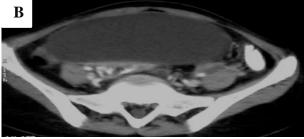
Computed tomography images. (A): Axial images of the same patient showing small bowel loops congregated in the centre of the abdomen encased by a soft tissue density membrane. Enlarged discrete lymph nodes are also seen in the mesentery (arrow head), (B): Loculated ascites is seen just below the level of conglomerate bowel loops.
